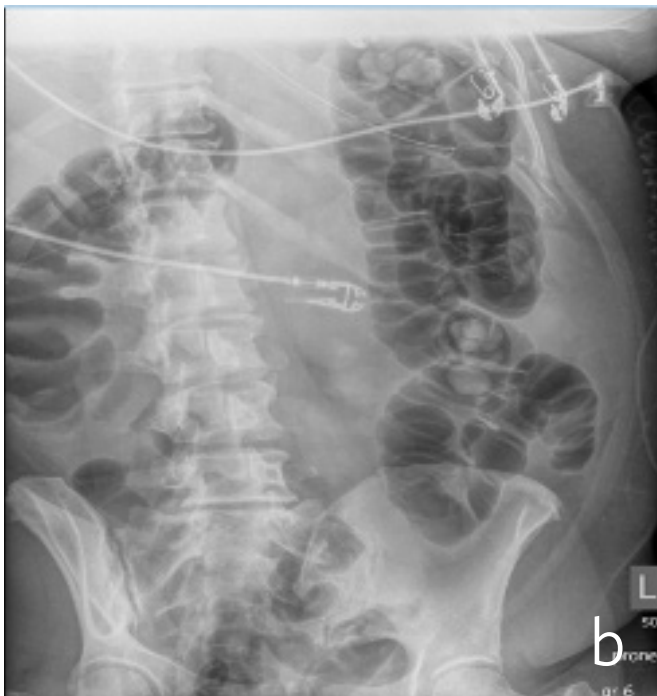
Case 2 CT imaging (a) abdominal X-ray showing predominantly diffuse colonic dilatation; (b) abdominal X-ray showing slight improvement in colonic dilatation; (c) abdominal X-ray showing complete resolution of colonic distension
